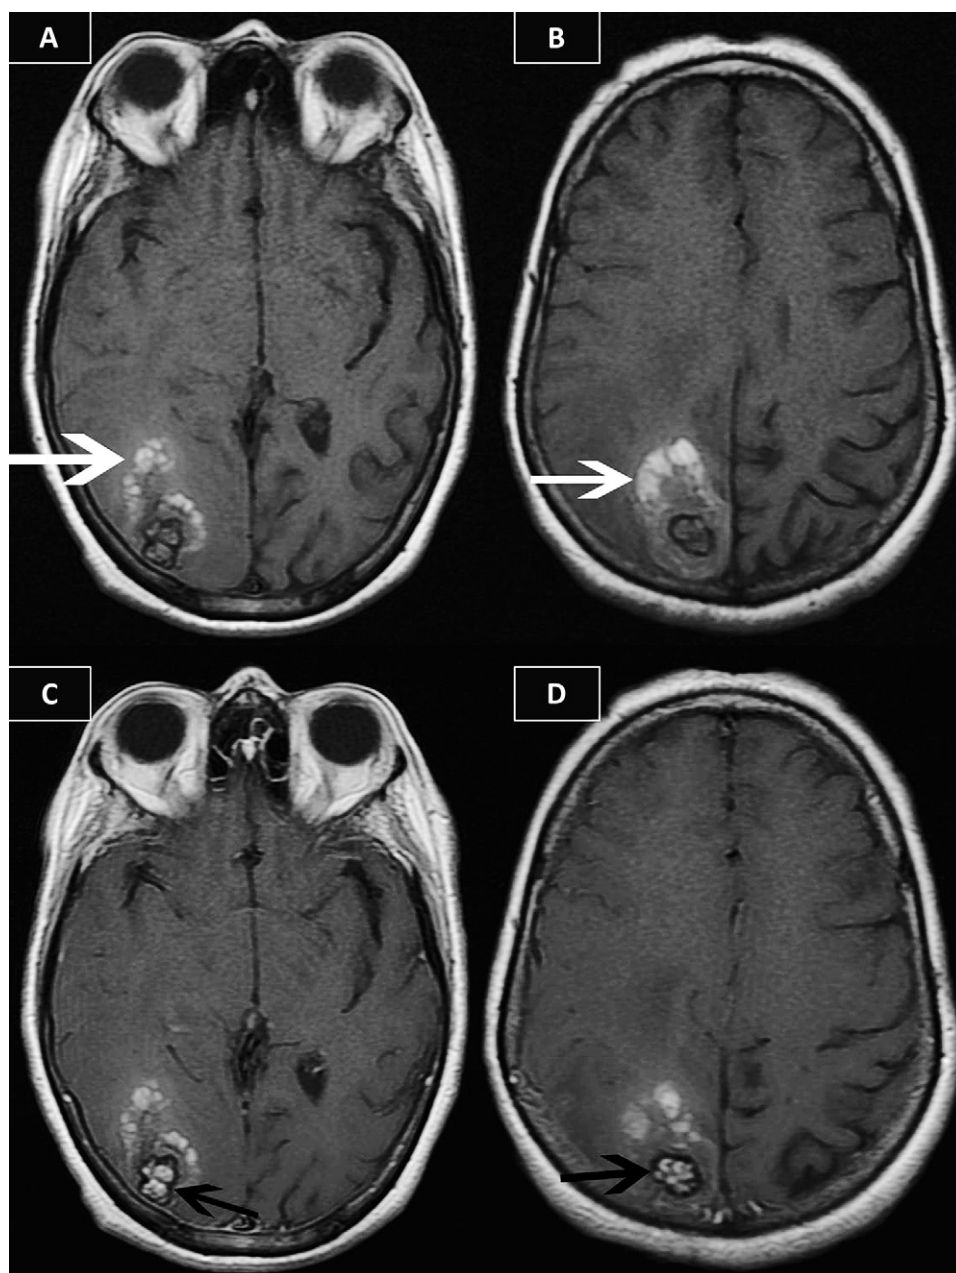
Magnetic resonance imaging of the head. (A,B) Axial T1-weighted images show high signal foci in the right occipital area representing hemorrhage (white arrows). (C,D) Axial T1-weighted images at same anatomic levels the after intravenous administration of gadolinium contrast demonstrate enhancement in central portions of lesions (black arrows). These findings are consistent with cavernous malformations of the brain.
